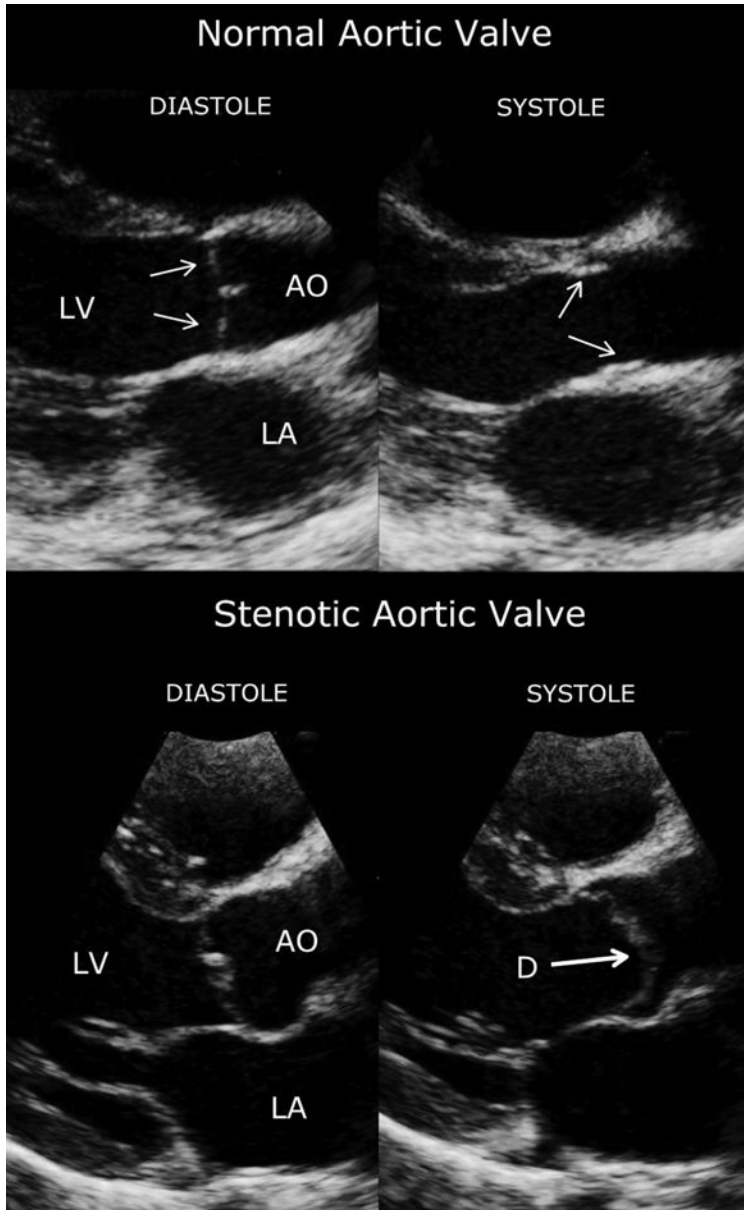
Long-axis echocardiographic views of normal (top) and stenotic (bottom) aortic valves. The cusps of the normal valve open completely such that they are oriented parallel to the aortic wall, whereas the stenotic valve cusps “dome” (D) during systole. LV, left ventricle; AO, aorta; LA, left atrium.
